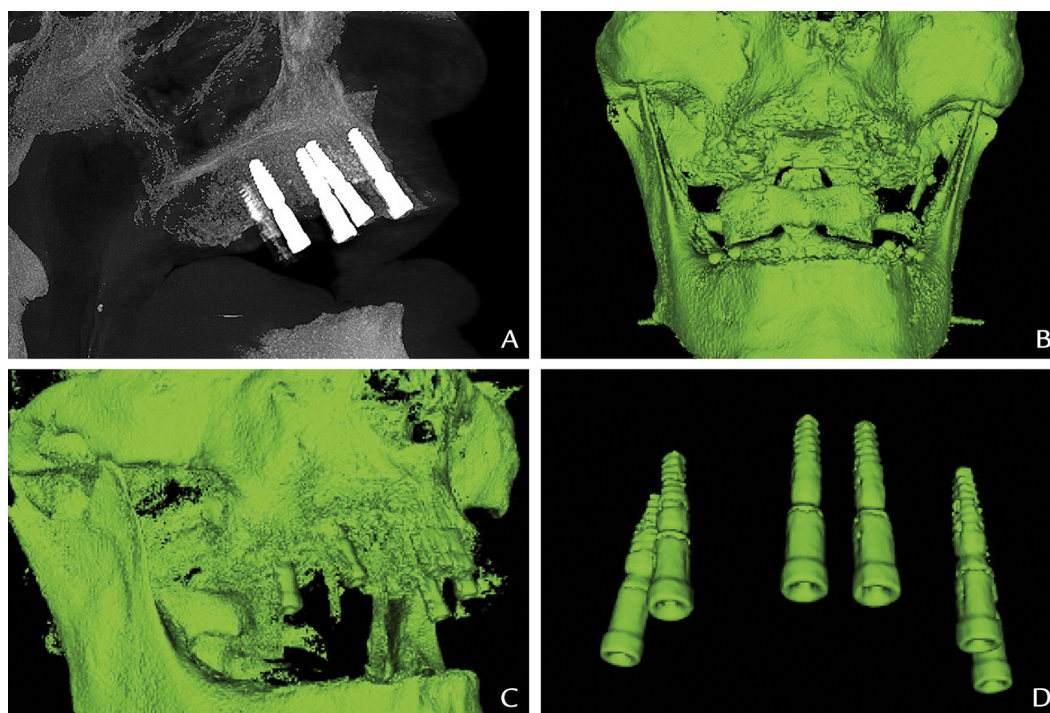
A, Postoperative CBCT scan with metal scan bodies (CBCT2). B, CBCT1 segmentation. C, D, CBCT2 segmentation. CBCT, cone beam computed tomography.
